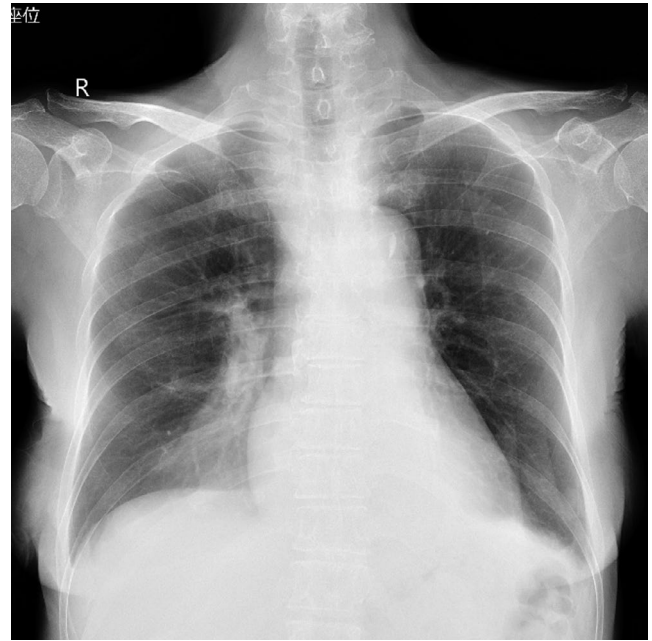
Chest X-ray obtained 4 days after the contrast agent injection. This figure shows that the contrast agent disappeared
